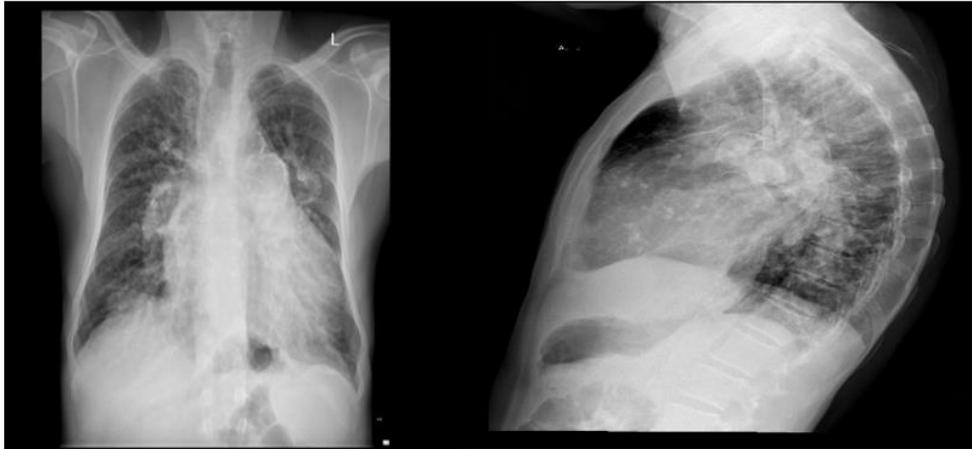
The chest X-Ray shows cardiomegaly and increased pulmonary marking (suggestive of pulmonary venous hypertension) with hilar prominence. Peripheral pruning is also present, and calcification is noted in the pulmonary bay region.
